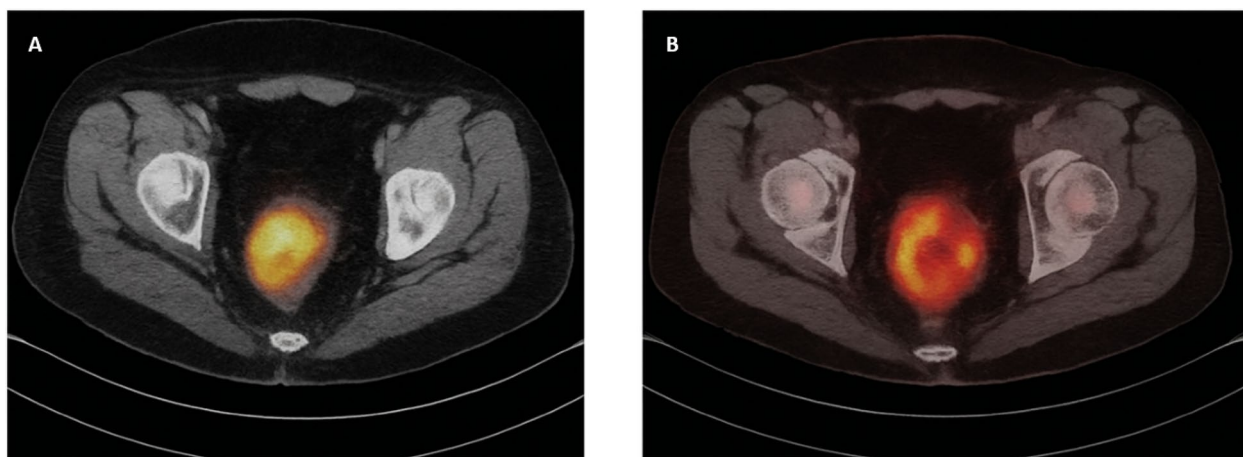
A Pre-treatment axial F-18 FDG PET/CT image of a patient with TRG1 (complete pathological response). The primary lesion in the rectum shows moderate FDG uptake (SUVmax: 12.3; MTV: 18 mL; TLG: 156). B Pre-treatment axial F-18 FDG PET/CT image of a patient with TRG5 (poor response). The lesion demonstrates intense FDG uptake (SUVmax: 22.7; MTV: 38 mL; TLG: 435)“
